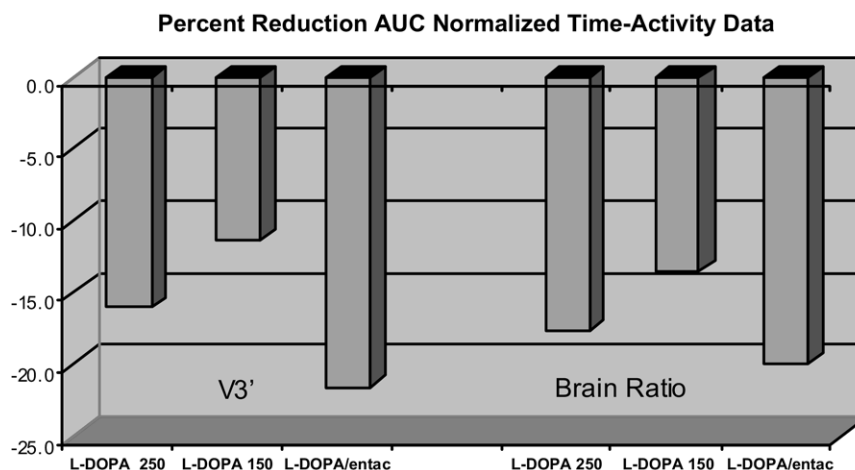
L-DOPA-induced reductions in 2 D2/D3 outcome measures (V3' and striatal:cerebellar ratio) in Parkinson's subjects ($n = 3$) undergoing bolus plus constant infusion with ^{123}I -IBZM and serial SPECT imaging for 10 hours. This small study demonstrates 12–23% reduction from baseline in a dose-dependent fashion following oral L-DOPA administration with an enhancement of the effect by the addition of entacapone. These studies provide a putative measure of intrasynaptic dopamine in the striatum. This technique is directly relevant to the mechanism of action for many dopamine replacement therapies in PD and may be used to directly evaluate the effects of drugs in human brain.
